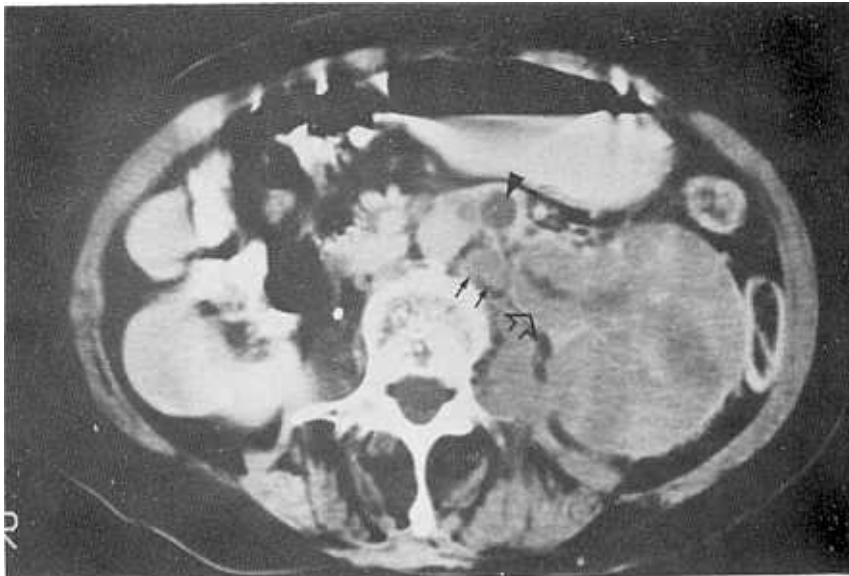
Abdominal CT scan shows an enlarged left kidney which is totally replaced by a hypodense mass (open arrow). A tumor thrombus (arrowhead) is in the left renal vein and an enlarged lymph node is noted in the left paraaortic area (black arrows.)
